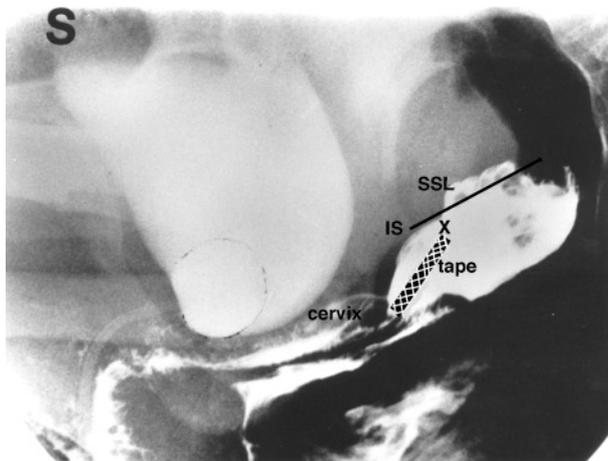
Xray of a nulliparous patient, straining. Same patient as figure 1. The tape and line of SSL have been superimposed on the original xray. Note the natural movement of the cervix and vagina activated by the posterior muscle forces. Whereas a tape allows such movements, fixation on SSL is far more rigid, and would inhibit them.
